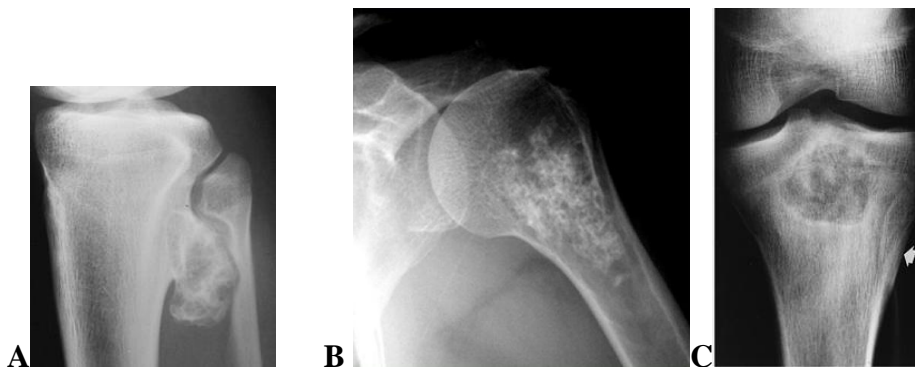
(A) AP radiograph demonstrates a proximal tibia osteochondroma. (B) Central enchondroma. Radiograph of the humerus showing a chondroid lesion with calcifications. (C) Chondroblastoma. AP radiograph demonstrates a proximal tibial lesion
